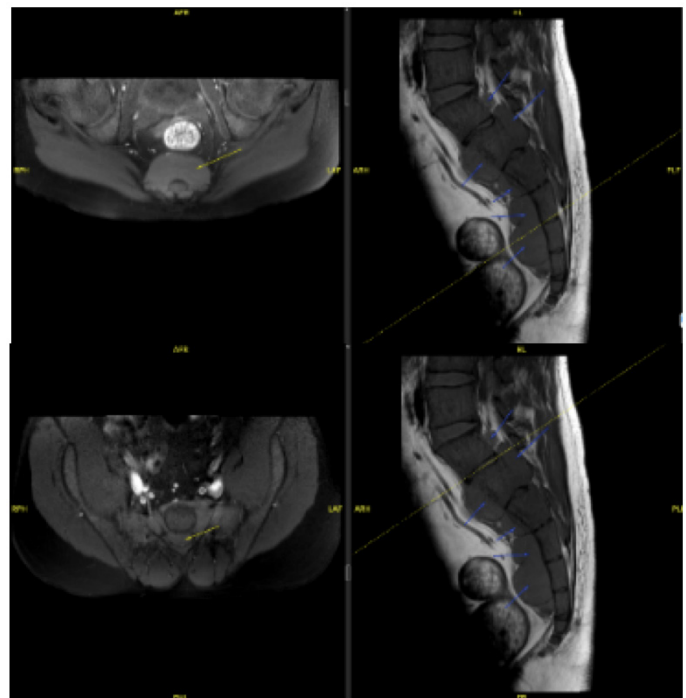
Spinal cord compression due to extramedullary hematopoiesis in MR imaging
